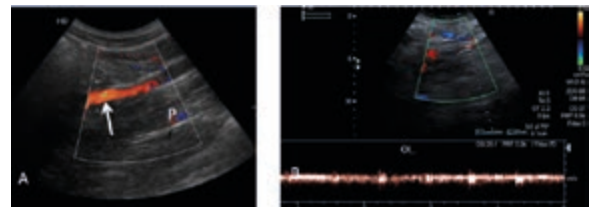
A) Longitudinal view at the left side level showing the dilated left gonadal vein (white arrow) with reflux after Valsalva maneuver; see its correlation with the psoas muscle (P). B) The spectral Doppler assessment performed on the longitudinal view of the left gonadal vein confirms the presence of venous reflux.
